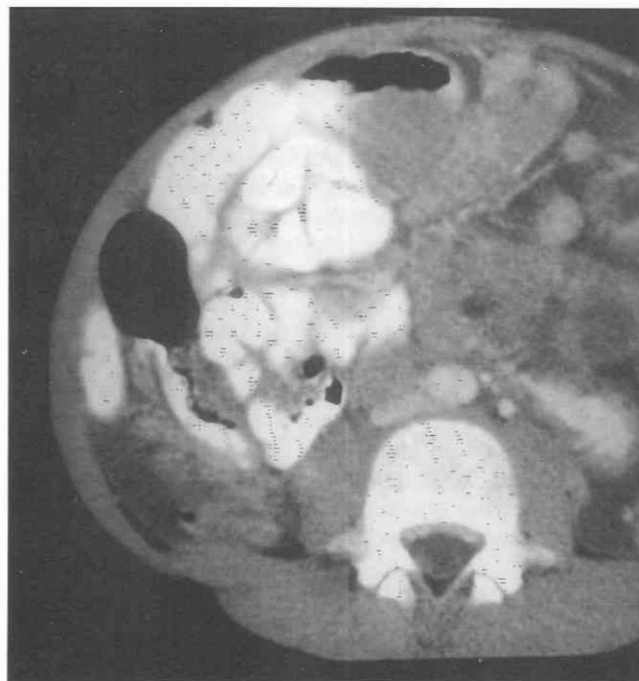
Non-Hodgkin's lymphoma involving the distal small bowel. CT scan through the lower abdomen in a patient with non-Hodgkin's lymphoma demonstrates bowel wall thickening involving the distal ileum. Note the associated mesenteric masses.
